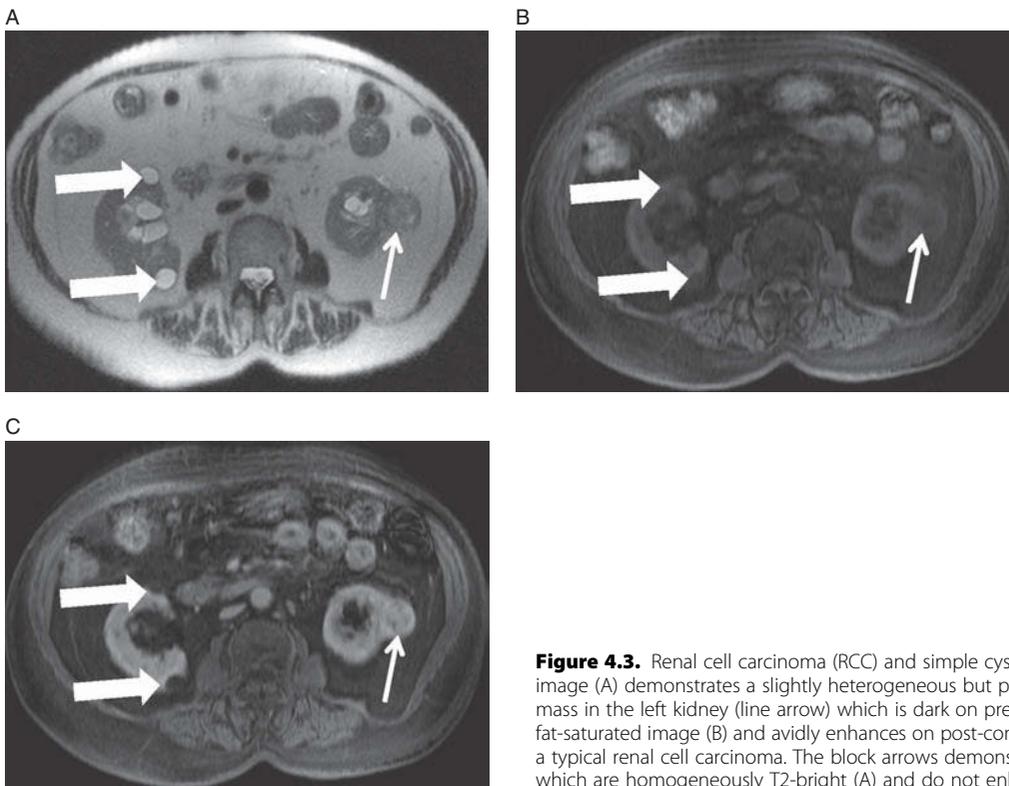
Renal cell carcinoma (RCC) and simple cysts. Axial T2-weighted image (A) demonstrates a slightly heterogeneous but predominantly T2-dark mass in the left kidney (line arrow) which is dark on pre-contrast T1-weighted fat-saturated image (B) and avidly enhances on post-contrast image (C). This is a typical renal cell carcinoma. The block arrows demonstrate simple cysts which are homogeneously T2-bright (A) and do not enhance (B, C).
